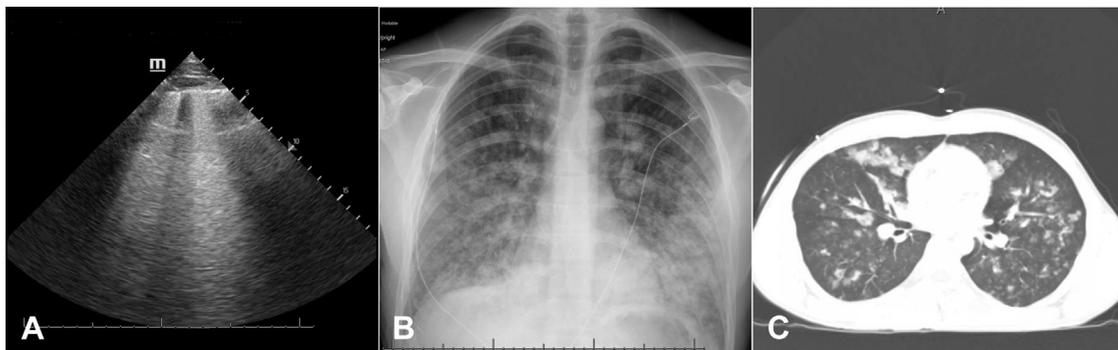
(A) Thoracic ultrasound image demonstrating copious B lines consistent with pulmonary edema. (B) Chest x-ray study with diffuse infiltrates and (C) computed tomography axial image with extensive mixed opacities with centrilobular predominance concerning for acute respiratory distress syndrome.
